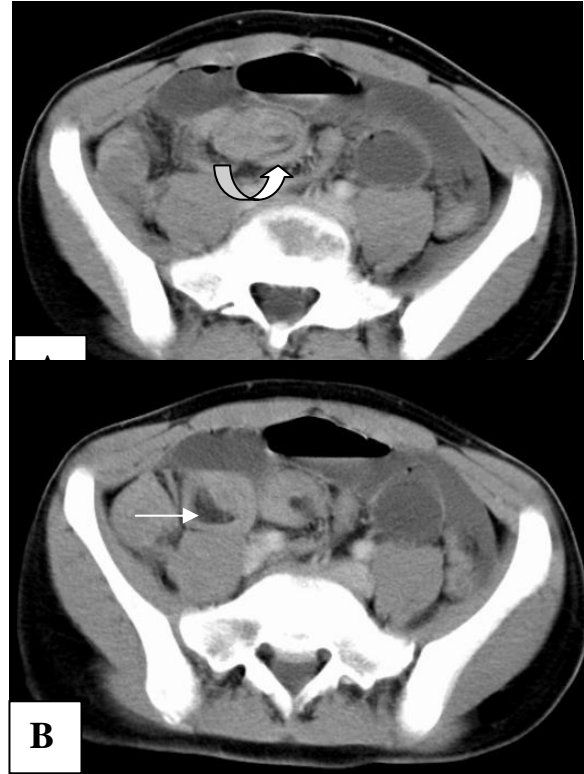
(A & B) CT scan of the lower abdomen showing two small bowel loops in the region of the terminal ileum that showed multiple concentric rings of tissue (curved arrow), and intra-luminal mass with fatty component (arrow) representing ileoileal intussusception.
